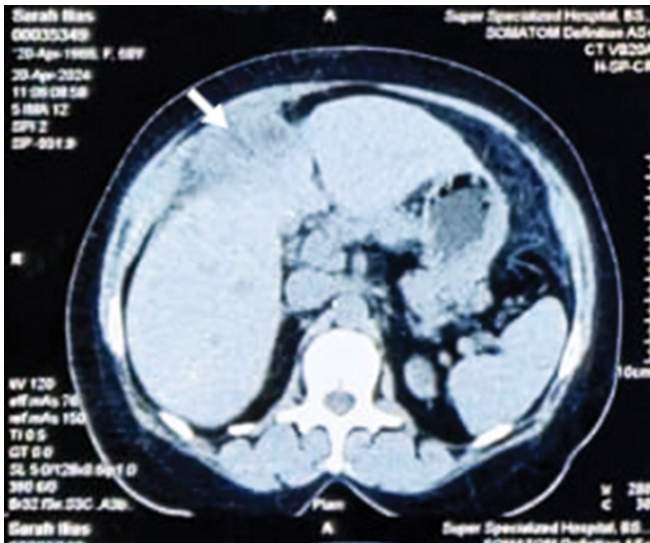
CT abdomen showing right sub-phrenic abscess (arrows)
